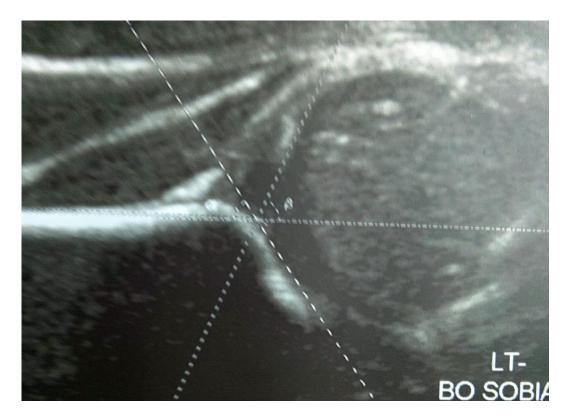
An ultrasound image from the current study of a 13 day-old-boy showing Graf type IIc hip with alpha angle 46 and beta angle 64 (centered hip-unstable).
